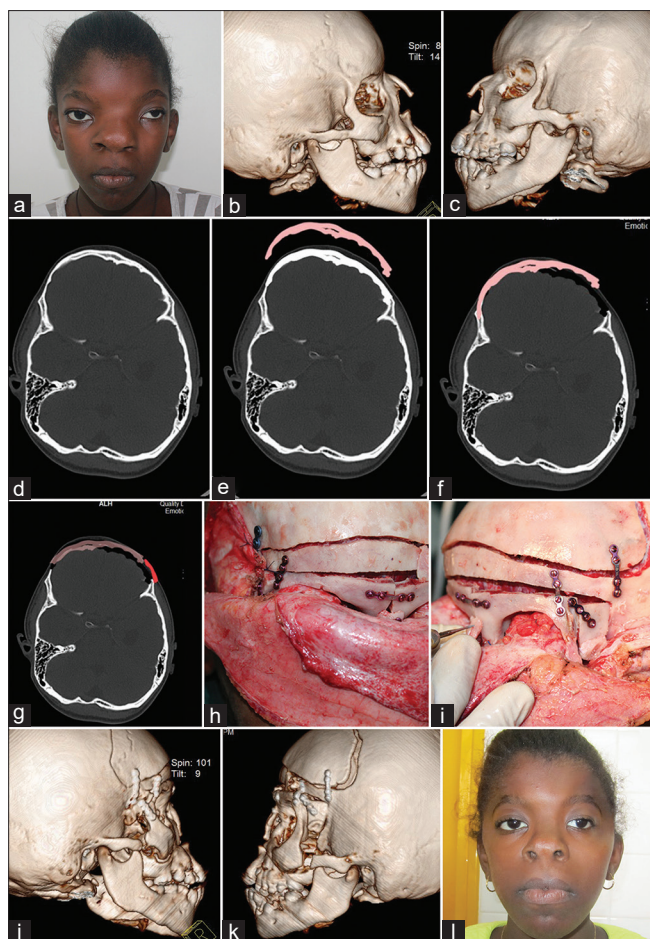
(a) Pre-operative view of a case of unicoronal synostosis with hypertelorism. (b) and (c) Preoperative 3D CT scan imaging. (d-g) The various sections show the images of the pre-operative planning for the calvarial segmental shift. (h-i) Intra-operative view showing rigid plate fixation (Titanium) at the frontozygomatic suture and at the upper orbital osteotomy site. (j-k) Postoperative 3DCT showing rigid plate fixation at the frontozygomatic and supra-orbital area. (l) Postoperative view showing better aesthetic appearance
